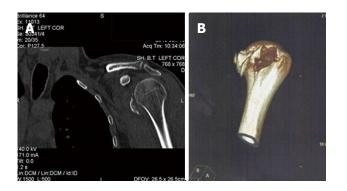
Further examination with computed tomography scan (A) and 3D computed tomography reconstruction (B) confirmed the diagnosis and revealed the comminution of the lesser tuberosity avulsion fracture.
